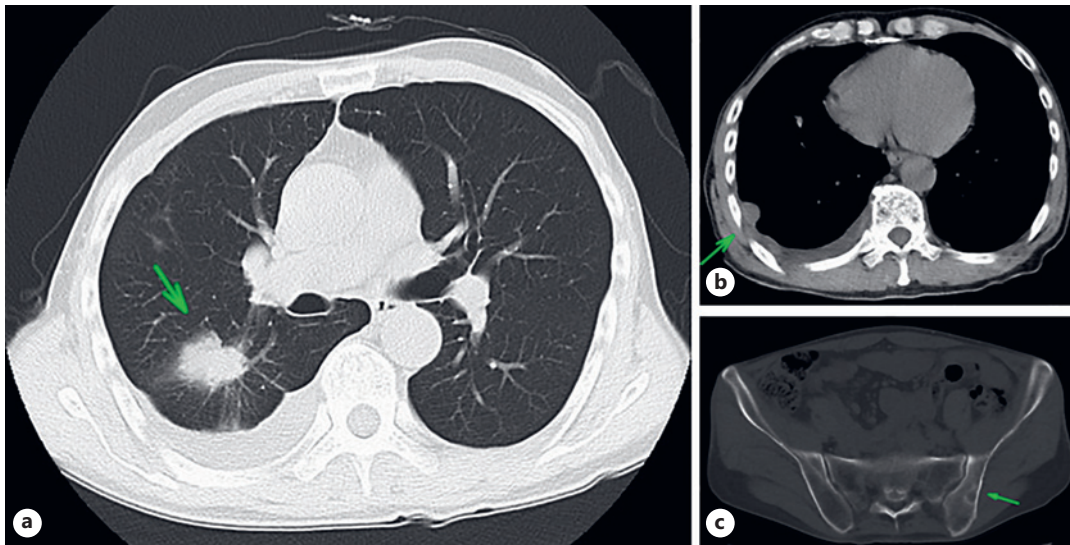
a–c A whole-body computed tomography scan revealed a right lower lobe lung tumor, pleural dissemination, pleural effusion, and metastasis to the left iliac bone (arrow).
